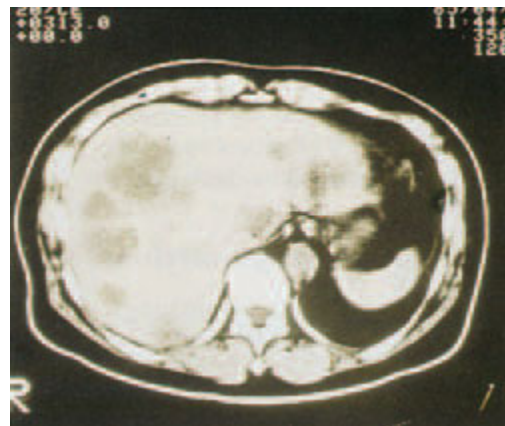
Haemangio-endothelioma. CT showing multifocal nodules.
